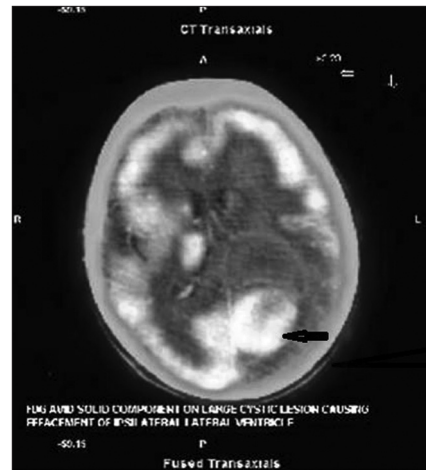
18 FDG PET/CT reported FDG uptake in enhancing solid component of large cystic lesion involving left parietooccipital region
